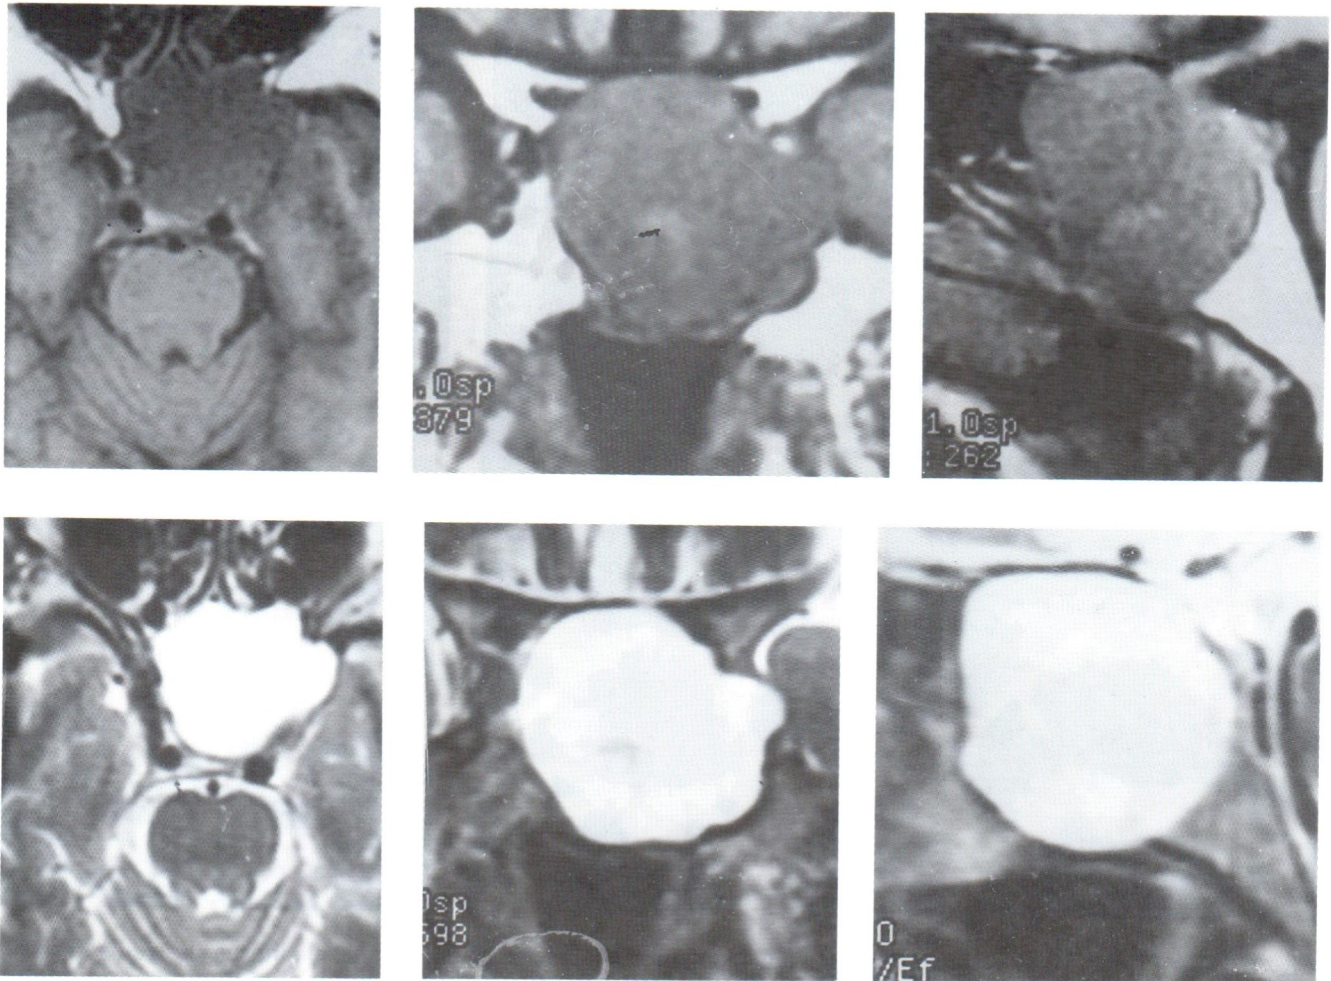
Case2. T1WI and T2WI-axial, coronal and sagittal view MRI study of the sphenoid sinus showed an expansion of the sphenoid sinus with pressure erosion to the anterior clivus, floor of the pituitary fossa, left cavernous sinus and medial left orbital apex. Left optic nerve was compressed at the apex. The lesion has a homogeneous signal, grey on T1WI and fluid bright on T2WI.
